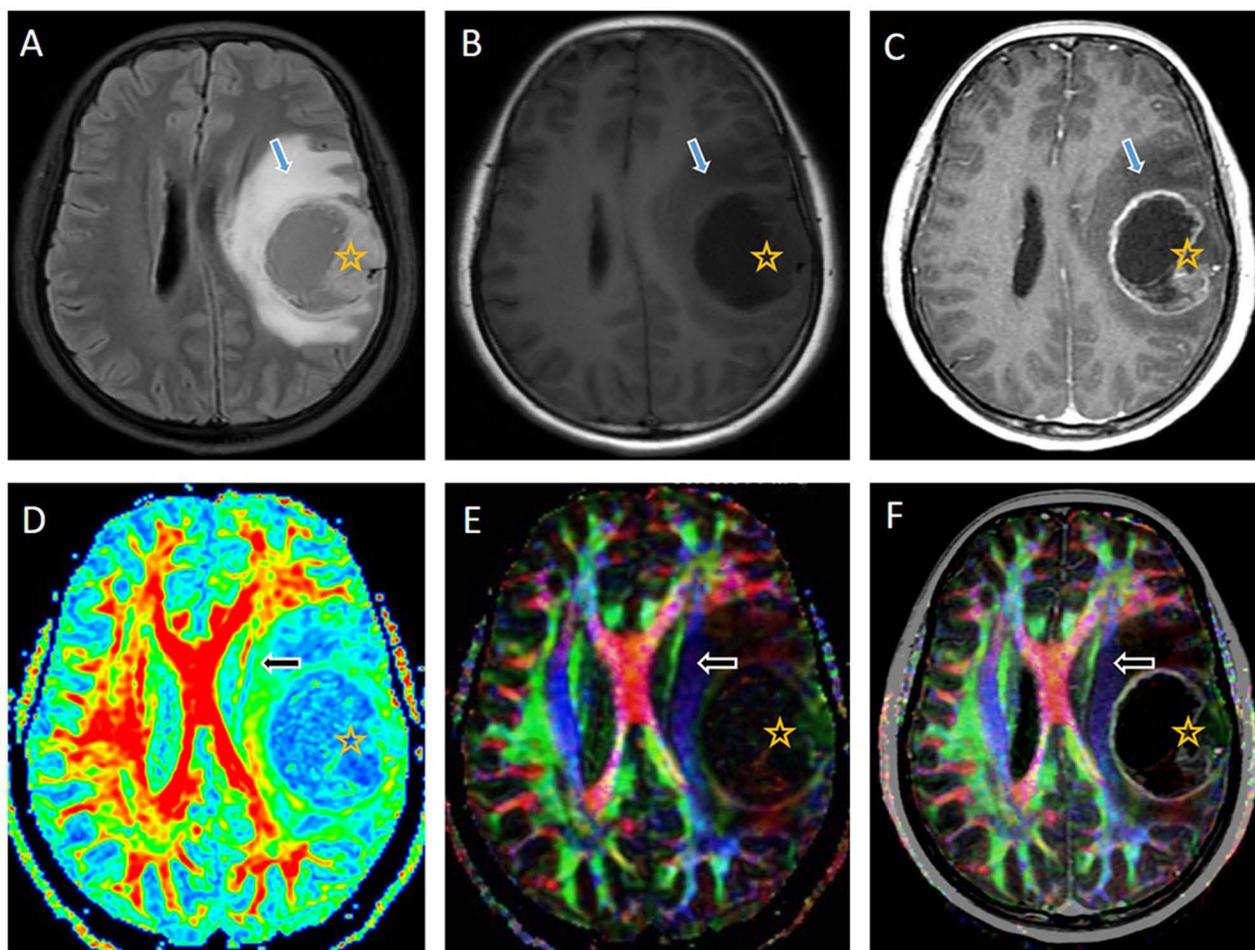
Diffusion tensor imaging of the brain of a 37-year-old woman with a left frontal anaplastic oligodendroglioma (grade III). Axial fluid-attenuated inversion recovery (A), pre-contrast T1-weighted (T1W) (B), and post-contrast T1W (C) images show a heterogeneous tumor (indicated by a star in A–F) with central necrosis, ring enhancement, and peritumoral infiltration (indicated by blue arrow in A–C). The tumor appears to infiltrate and medially compress the left corticospinal tract (CST) (indicated by black arrow in D–F). The combination of the color-coded map and post-contrast T1W (F) shows tumor contact with the left CST, leading to a glioma-to-CST distance of 0 mm.
